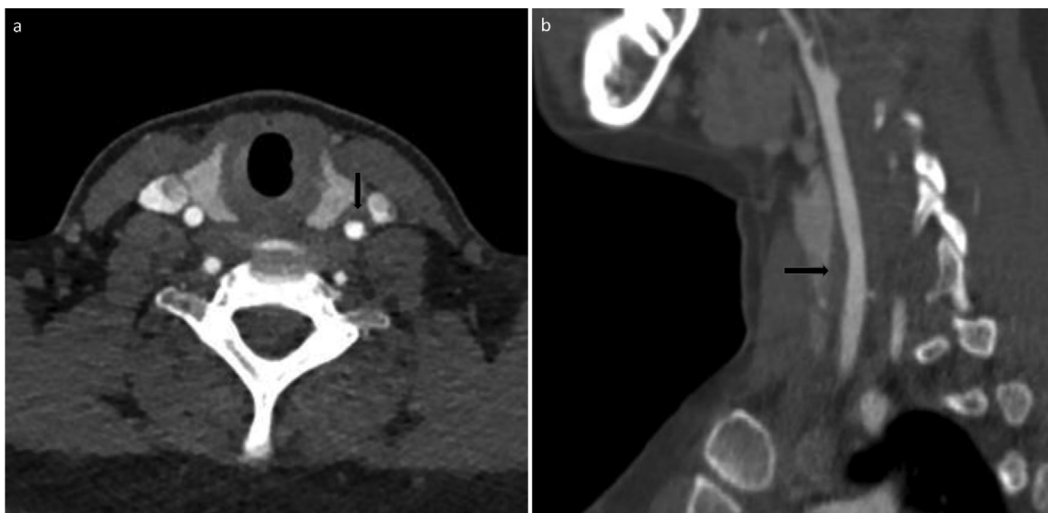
Focal common carotid artery dissection. Axial (a) and sagittal (b) CT angiography images shows focal periarterial haematoma related to focal dissection (arrows in a and b).
